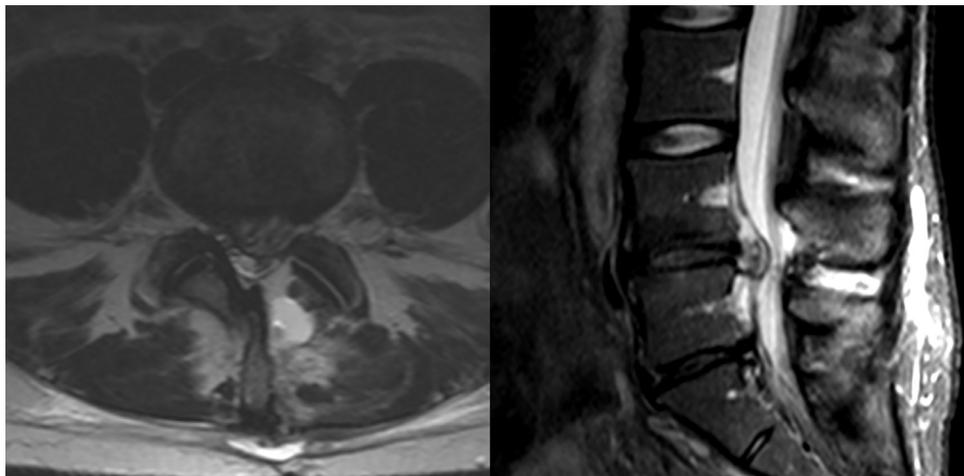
Recurrent disc herniation. Patient had undergone left L4 hemilaminectomy and microdiscectomy with some initial improvement in symptoms. However, the patient soon presented with recurrence of symptoms and MRI was obtained showing recurrent paracentral left L4-5 disc protrusion.
